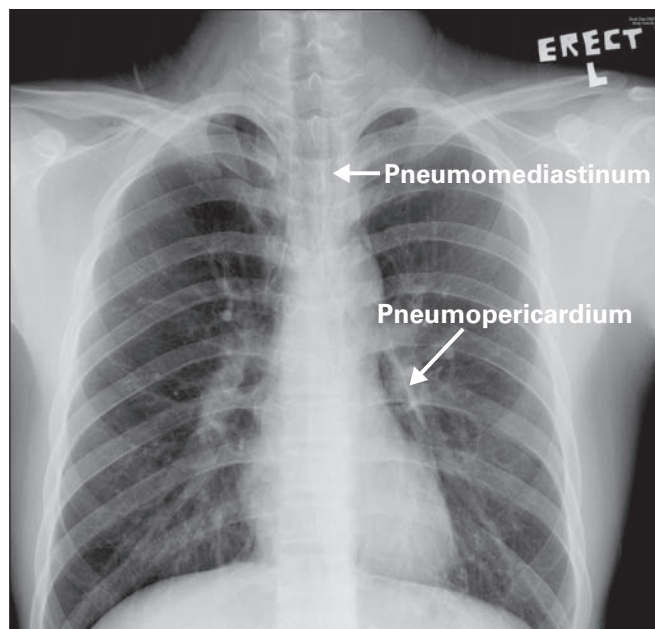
A chest radiograph confirmed pneumopericardium and pneumomediastinum.
